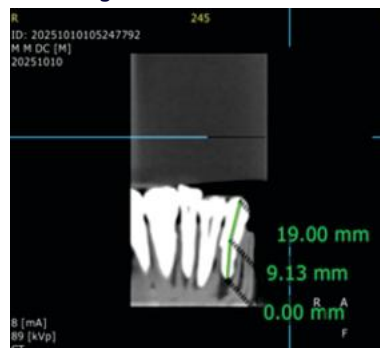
Working Length Measurement by CBCT
